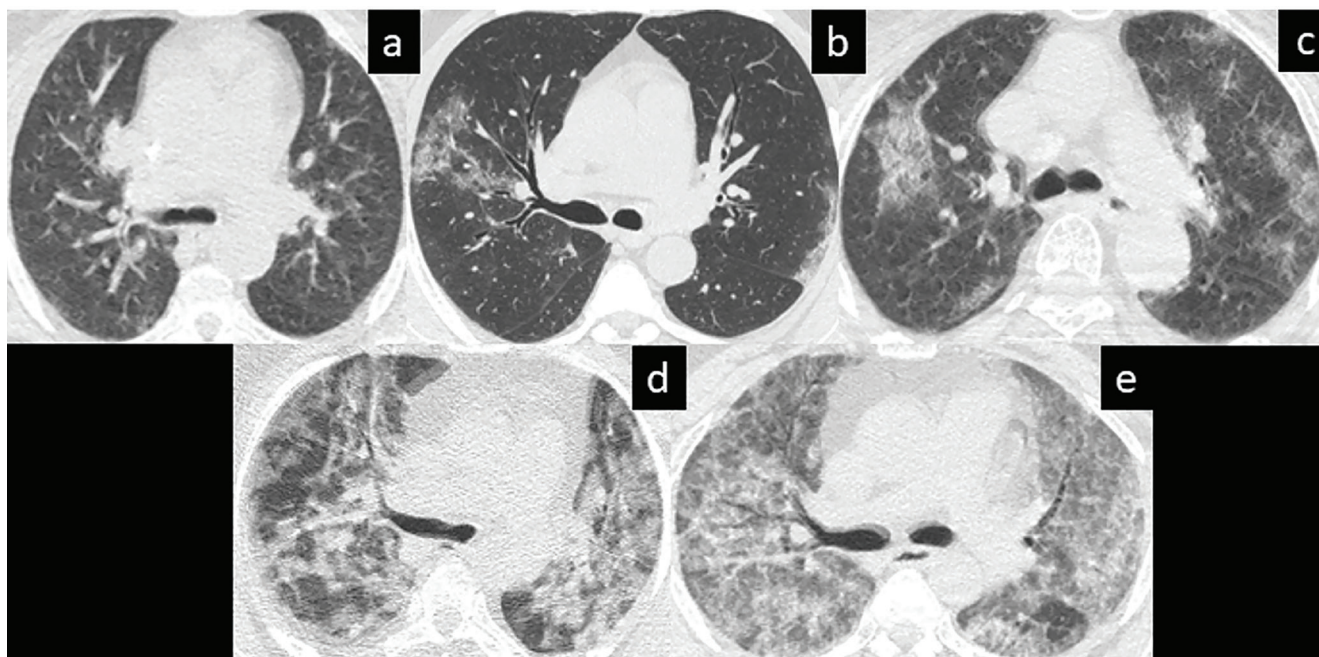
The exemplary chest CT images of COVID-19 patients with CT-SSs of 5 (a), 10 (b), 15 (c), 20 (d), and 25 (e). These CT images show less than 5% involvement, 5%-25% involvement, 25%-50% involvement, 50%-75% involvement, and more than 75% involvement, respectively
